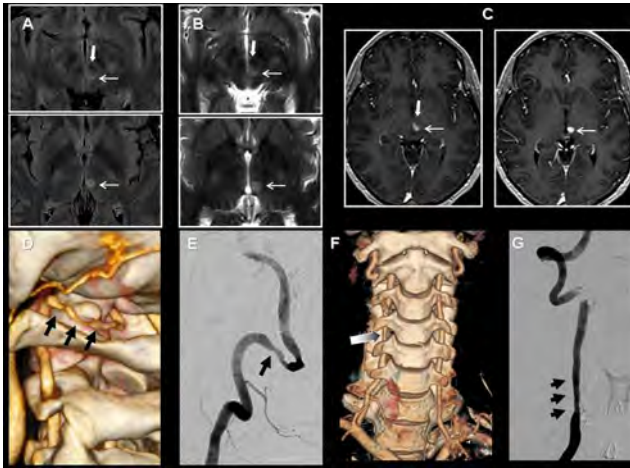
A, B. Axial FLAIR (A) and axial T2-weighted images (B): hyperintense lesion (white thin arrows) in left midbrain pre-tectum and medial inferior part of the left thalamus. (red nucleus=white thick arrow). C. Axial 3D-spoiled gradient-recalled (SPGR) T1-WI post-contrast: homogeneous enhancement of the lesion. D. 3D Volume-Rendered (VR) post-contrast CT angiography (CTA): focal narrowing and irregularity of the lumen (black arrows-V3 segment). E. Digital Subtraction Angiography (DSA). Lateral projection of left vertebral artery: The image correlates with CTA (black arrow). F. 3D VR post-contrast CTA: Narrowing of intraforaminal segment (V2) of right vertebral artery (thick grey arrow). G. DSA. Antero-posterior projection of right vertebral artery: smooth focal tapered narrowing of V2 segment.
